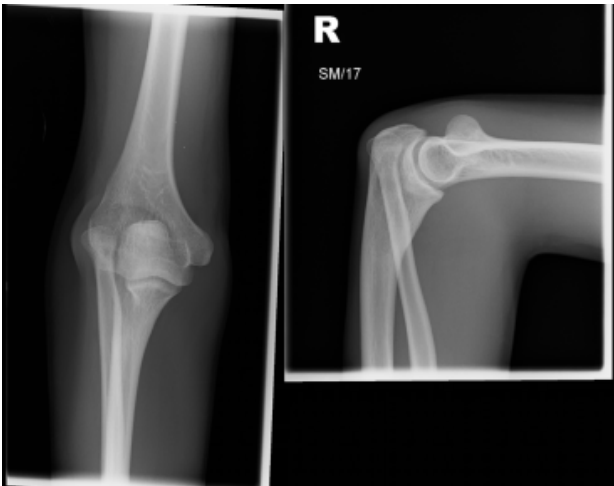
Radiographs of Right Elbow AP, Lat views.
